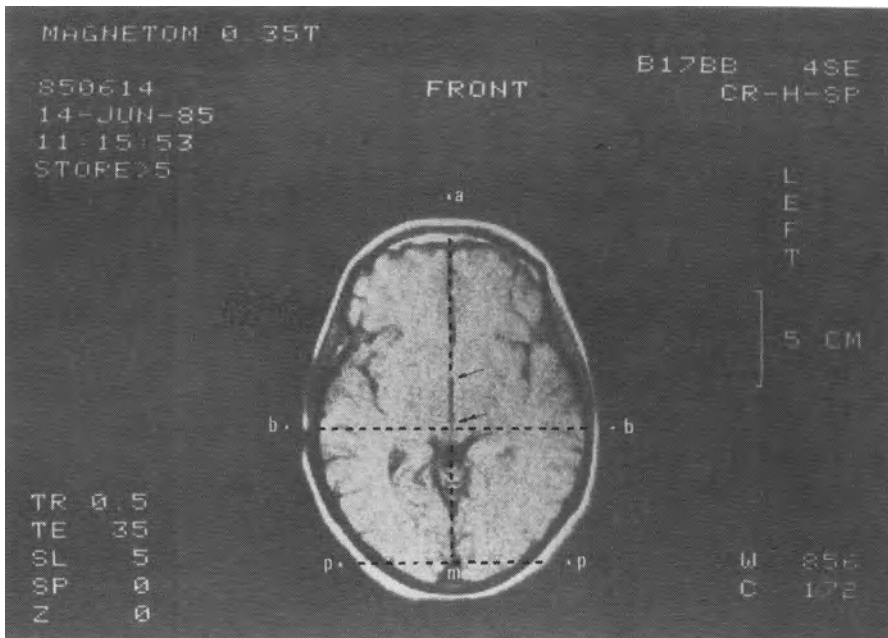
MRI with the adapter. Determination of the target coordinates is similar to that of a CT study. Fluid-filled plastic tubes attached to the reference structures of the adapter are clearly visible. The arrows indicate the anterior and the posterior commissures.
